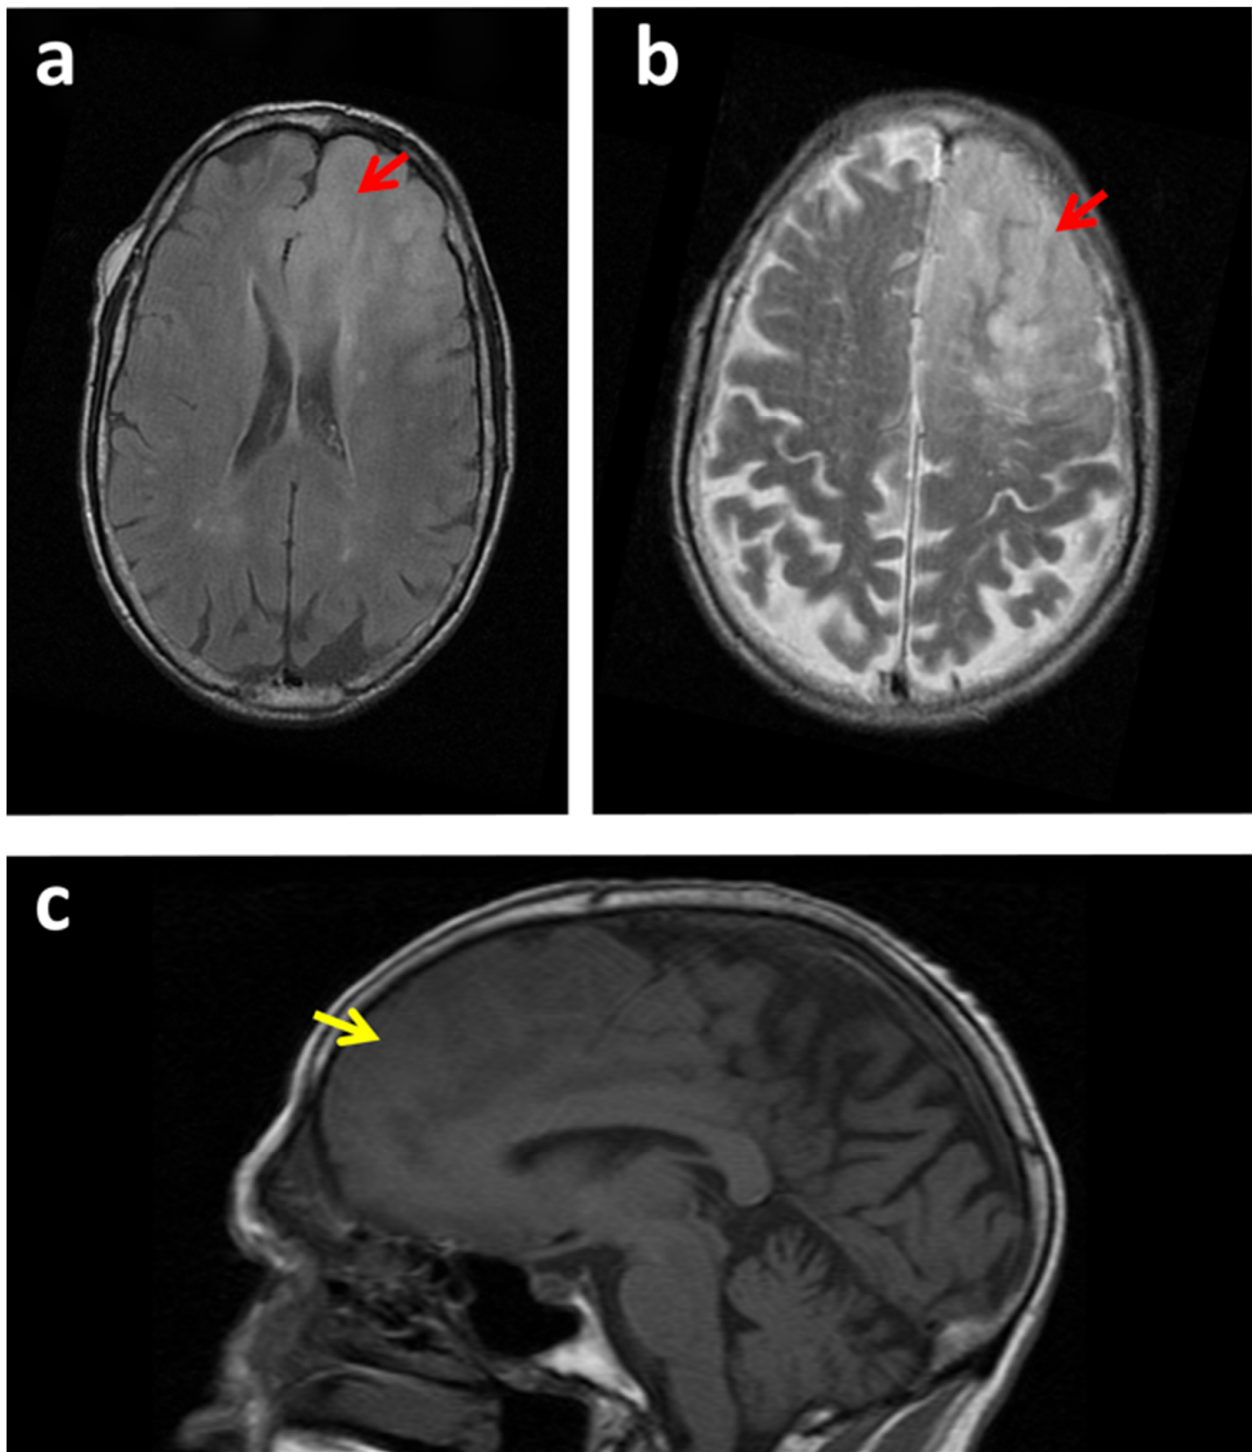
MRI scans of a case of glioma that could be confounded with an ischemic stroke. (a–c) MRI images of a patient with a glioma in the right frontal lobe (red arrows). (a) Inversion recovery fast spin-echo (IRFSE) Fluid-Attenuated Inversion Recovery (FLAIR), axial MRI. (b) Axial FSE T2 MRI image. (c) Spin-echo (SE) T1 sagittal MRI image. The space-occupying lesion could be confounded with an ischemic stroke in evolution (yellow arrows). Loss of gray and white matter differentiation. The lesion was confirmed to be a diffuse tumoral mass compatible with grade II astrocytoma by anatomopathological analysis.
